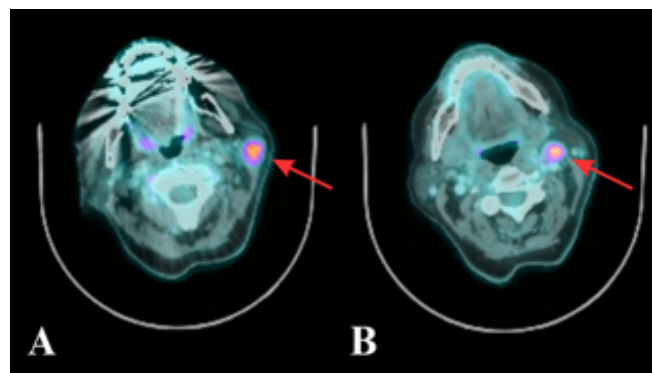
A very intensely FDG-avid mass is centred within the left preauricular soft tissues, extending into the superior aspect of the left parotid gland, located just below the skin surface (red arrow) (A). A second, smaller, nodular/mass-like component extends outward from the inferior portion of the left ear, just inferior to the external auditory canal (EAC) (red arrow) (B).
